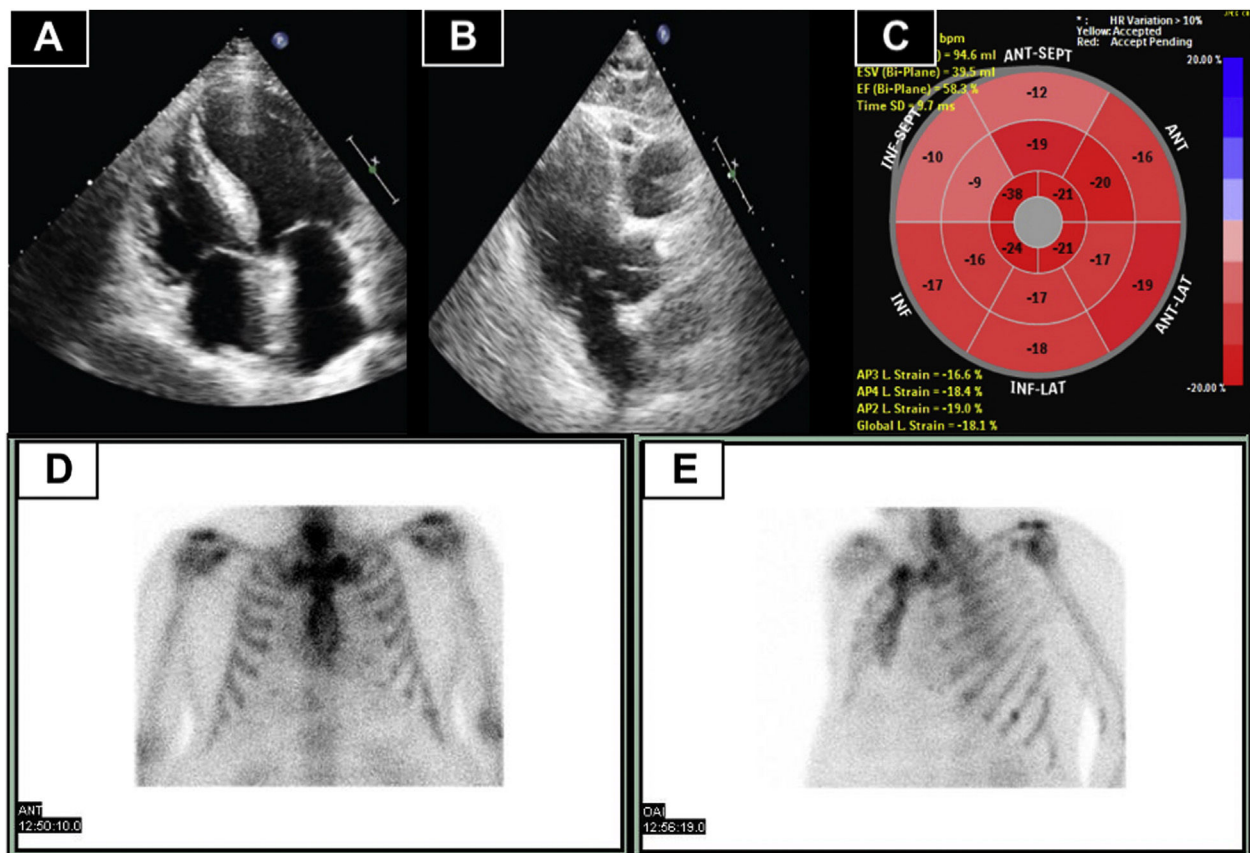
A and B: transthoracic echocardiography showing basal septal thickening. C: global longitudinal strain pattern of the left ventricle, with reduced values, particularly in the basal and mid-anteroseptum and inferoseptum. D and E: myocardial perfusion imaging showing absence of cardiac uptake (Perugini score, 0). ANT, anterior; ANT-LAT, anterolateral; ANT-SEPT, anteroseptal; INF, inferior; INF-LAT, inferolateral; INF-SEPT, inferoseptal.
